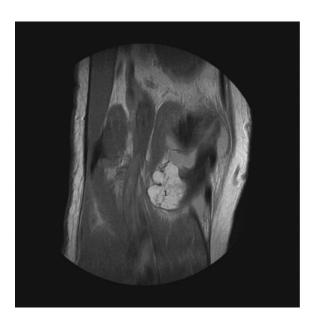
71-year-old female with lipoma arborescens. Coronal T1-weighted MRI of the right knee shows a focus of lipoma arborescens (1).
